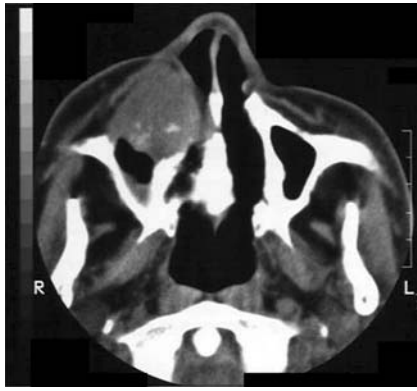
CT scan shows a tumor with bone destruction in the right maxillary sinus
